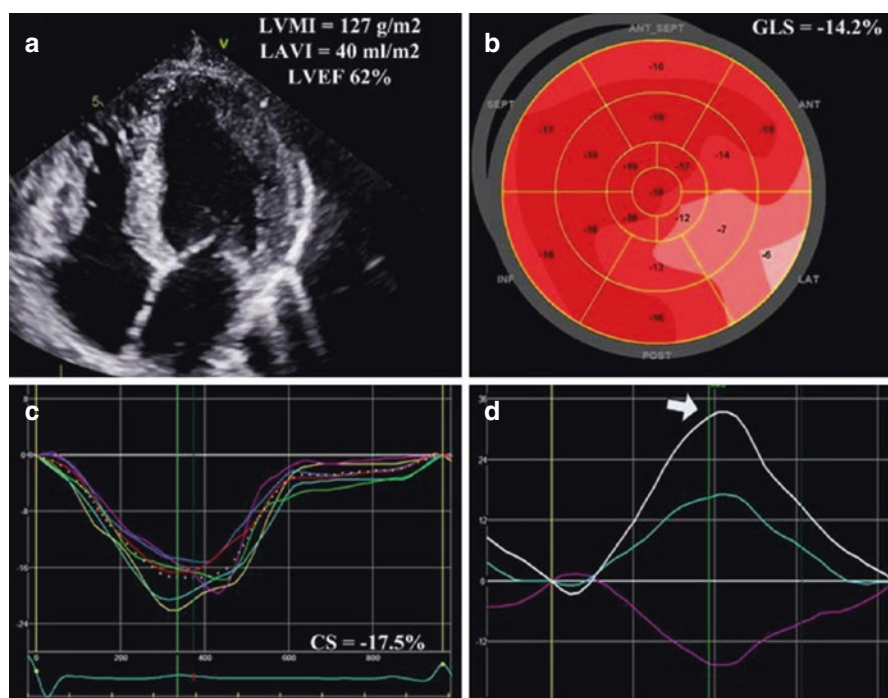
Echocardiographic findings in a patient with heart failure with preserved ejection fraction. Two-dimensional echocardiogram demonstrates increased left ventricular mass, enlarged left atrium, and preserved left ventricular ejection fraction (panel a). Global longitudinal strain is significantly decreased (panel b). There is also impairment of the circumferential strain (panel c) while the left ventricular twist is exaggerated (panel d, arrow)
